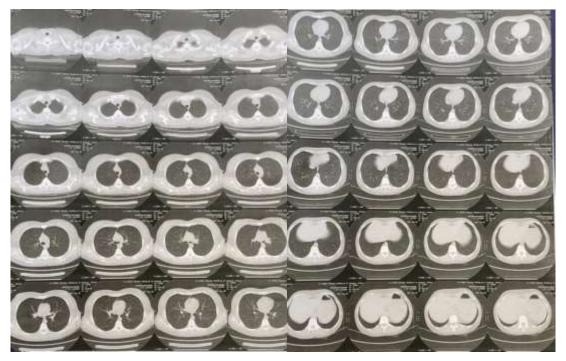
The chest Computer tomography (CT) scan result
